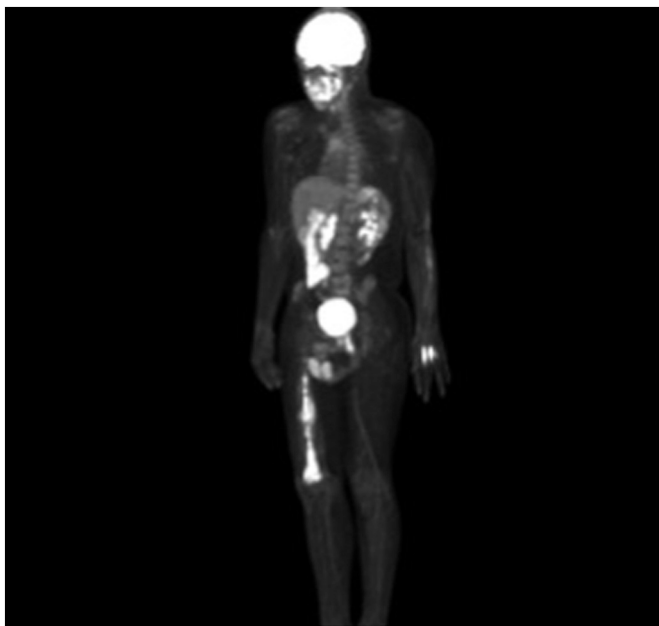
PET scan shows findings compatible with metabolically active process within the majority of the right femur including some soft tissue alongside the femur. SUV max 8.24 mid femoral shaft. The findings, especially given the PET appearance of the femur and the biopsy results of the femur, are very concerning for femoral and left long and ring finger metacarpal recurrent disease.
